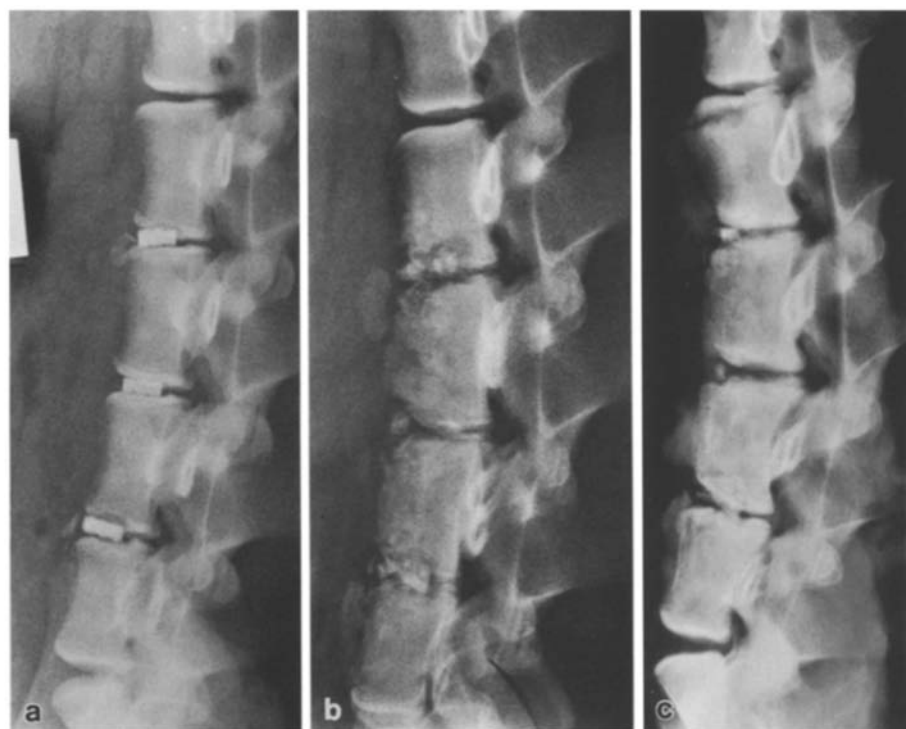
a Lumbar spine of minipig A after insertion of the three different kinds of hydroxyapatite implants into the L4–7 intervertebral spaces. b Plain film of minipig A at 6 weeks. Implant ossification is not visible. The residual height of the cranial IP-PGA implant is 86%, that of the middle Patka-PLA 66%, and the caudal IP-PLA implant has retained its initial height. All the implants are fragmented, all the vertebral endplates are rough and osteolytic, and the cranial and caudal ones are slightly fragmented. c Plain film of minipig A at 24 weeks, revealing marginal osteoconductive bridging alongside the implant at the cranial IP-PGA implant as well as at the caudal IP-PLA implant, more pronounced at the latter. The implants have continued to lose height and volume, and fragmentation is fulminant: extensive anterior longitudinal ligamentous calcification and thickening, posterior spondylosis at the L3–6 levels, encroaching slightly on the sagittal spinal canal. Compared to the first postoperative radiograph, there is a uniform 10° increase in lumbar kyphosis. Note also the complete epiphyseolysis at the L4 cranial endplate
